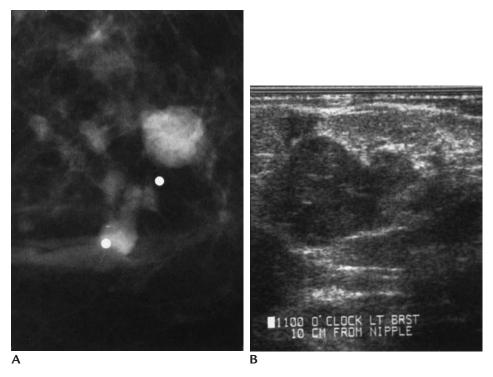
Multiple papillary carcinomas. (A) Multiple well-circumscribed masses. Some of the smaller masses are lobulated and have ill-defined margins. The metallic BBs mark two palpable masses corresponding to the two largest lesions. (B) Hypoechoic lobulated mass corresponding to the largest of the masses imaged mammographically. Peripheral papillary carcinomas are commonly multiple and solid on ultrasound. In contrast, papillary carcinomas occurring in the subareolar area are commonly solitary and imaged as a complex cystic mass on ultrasound.
